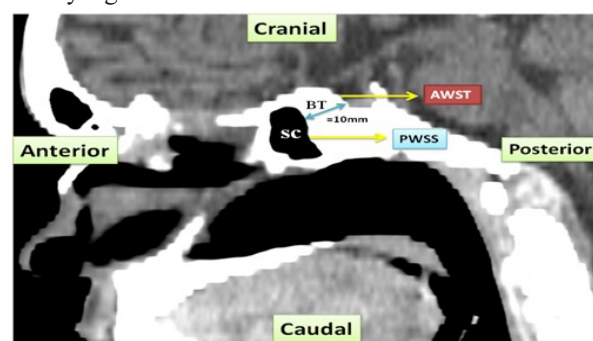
A sagittal CT slide of sphenoid sinus of a 78-year-old female demonstrating the conchal type of pneumatization. BT = Bone Thickness ($> \text{or} = 10\text{mm}$), AWST = Anterior Wall of Sellar Turcica, PWSS = Posterior Wall of Sphenoid Sinus, SC = Sinus Cavity
